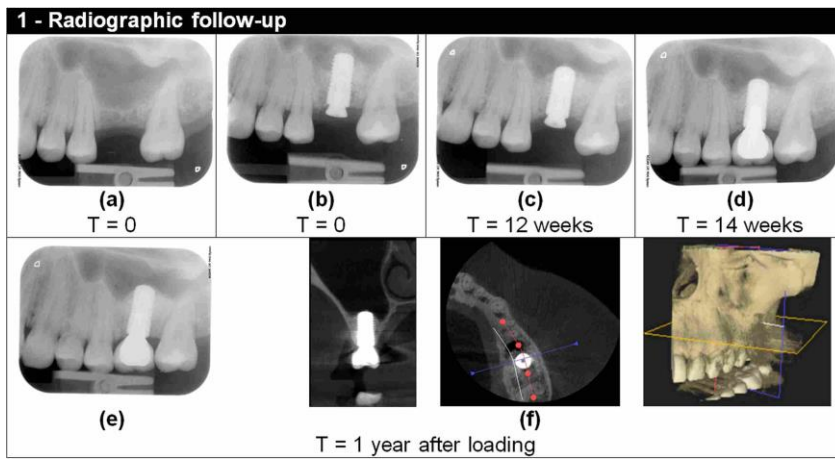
Radiographs and clinical views of posterior area of Patient 12.
